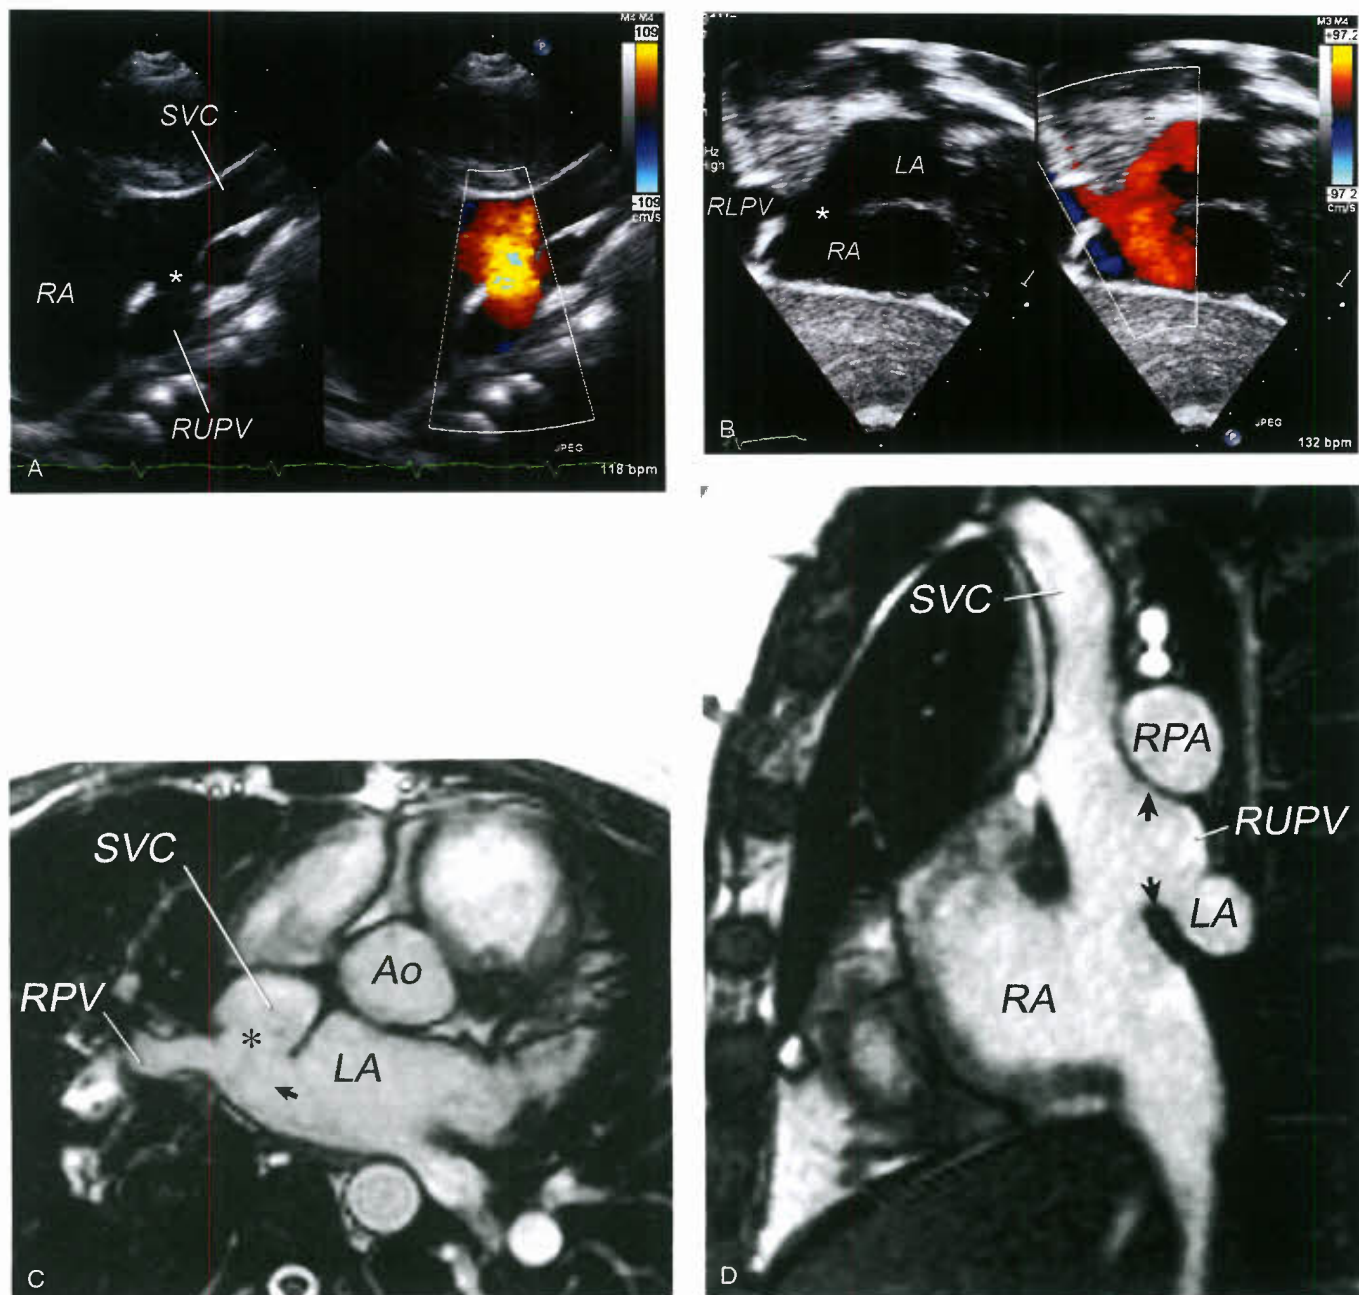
Sinus venosus defect. Echocardiogram (A,B) and MRI (C,D) of sinus venosus defect. A: Transthoracic right sternal border view in a patient with SVC-type sinus venosus defect. The deficiency in the wall between the right upper pulmonary vein (RUPV) and the SVC is the sinus venosus defect. The interatrial communication is the orifice of the right upper pulmonary vein (asterisk). B: Subcostal oblique view in a patient with inferior-type sinus venosus defect with color Doppler comparison. Note the absence of tissue (asterisk) between the right lower pulmonary vein (RLPV) and right atrium (RA), with flow directed into the right atrium (red flow) from both the RLPV and the LA through the RLPV's normally connecting orifice. C: Axial plane cine MRI image showing the defect (asterisk) in the tissue that separates the posterior wall of the SVC and the anterior wall of the right upper pulmonary vein (RPV). The arrow indicates the left atrial orifice of the right upper pulmonary vein, which serves as a communication between the LA and the SVC (Ao, aorta). D: Sagittal plane cine MRI: The arrows indicate the sinus venosus defect between the right upper pulmonary vein (RUPV) and the SVC. LA, left atrium; RA, right atrium; RPA, right pulmonary artery.
